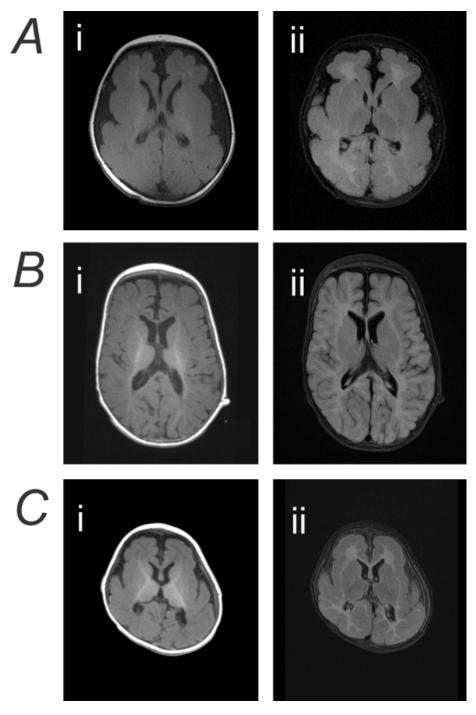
Magnetic resonance imaging scans of individuals with SCN3A-related neurodevelopmental disorder
